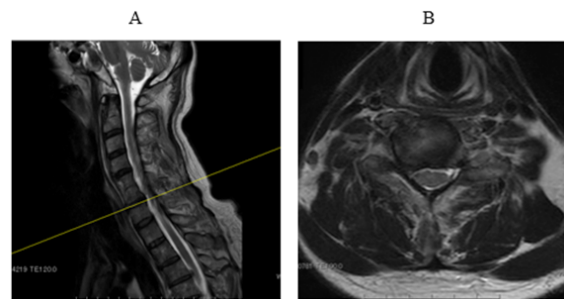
Cervical spine MRI image taken during hospitalization at Hospital B. A: Sagittal section at the C6/7 level. B: Horizontal section at the C6/7 level showing compression of the right nerve root. MRI, magnetic resonance imaging
